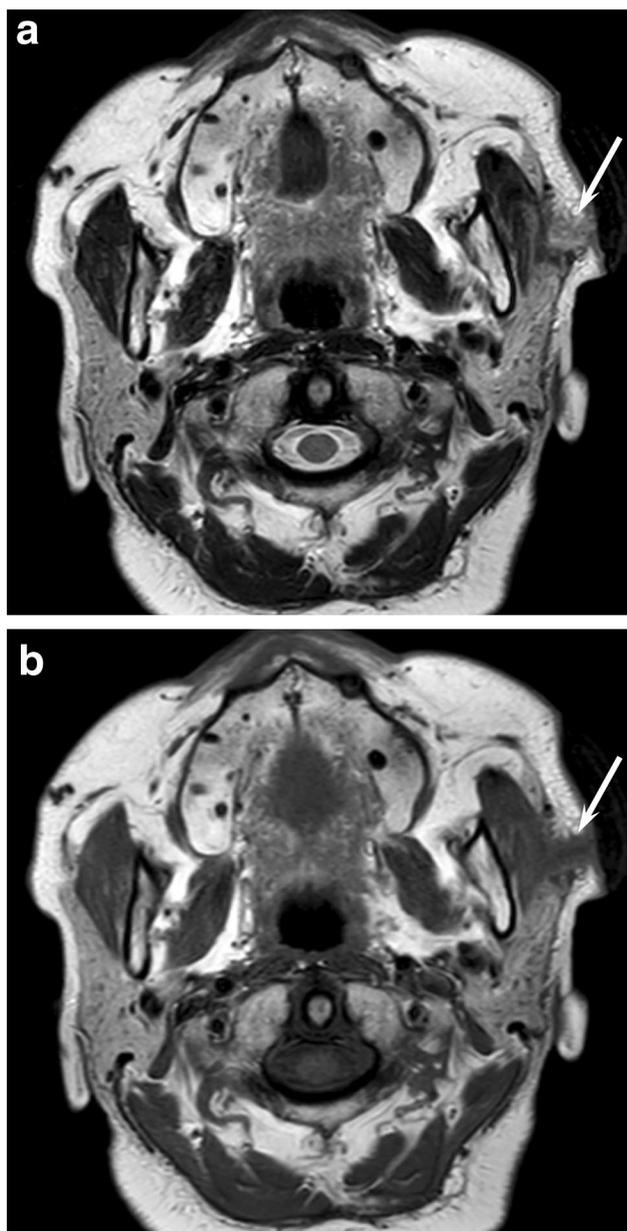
A 69-year-old woman with sialocele occurring after surgery for removal of pleomorphic adenoma of the left parotid gland. a T2-weighted image shows fluid collection (arrow) corresponding to the site of operation. b T1-weighted image shows hypointense fluid collection (arrow)
